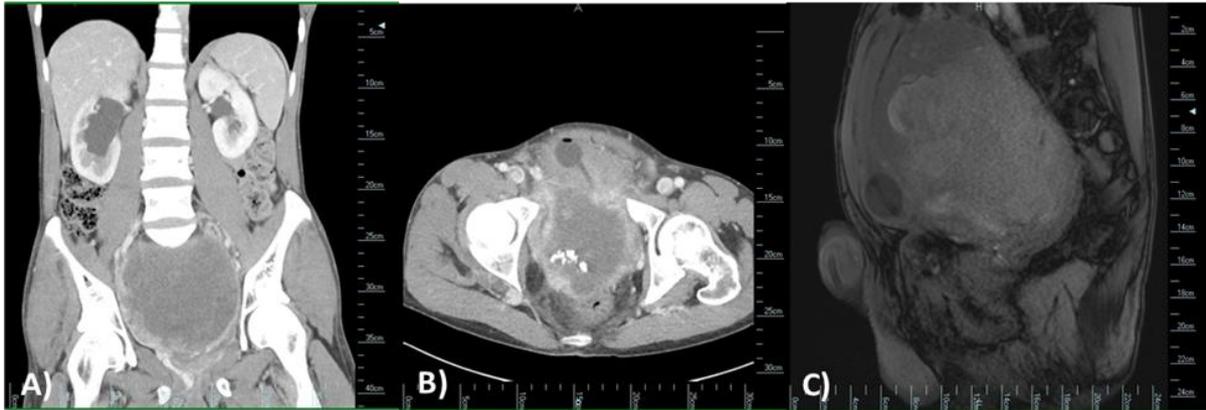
Contrast enhanced CT (CECT) of abdomen showing A) Large heterogenous tumor in pelvis with peripheral serpiginous enhancement, B) Lesion does not clearly invade the surrounding adjacent structure, C) MRI of pelvis showing mass contacting posteriorly lumbosacral junction but without direct invasion
